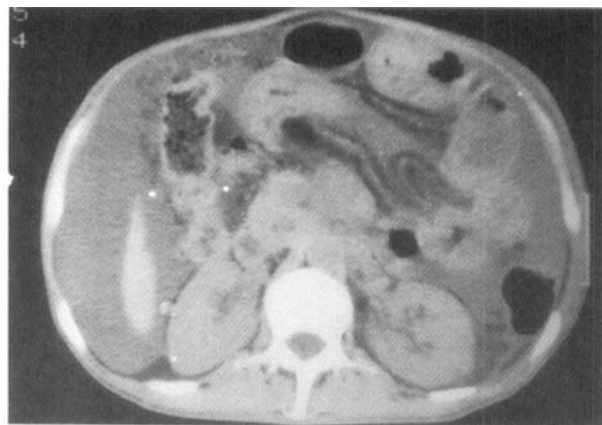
CT-scan of patient W.S. with a metastatic carcinoid tumour and total duodenal stenosis before (left) and after (right) 12 months' treatment with octreotide $2 \times 100 \mu\text{g}$ s.c. daily. The tumour mass and the ascites have disappeared in the control scan.
